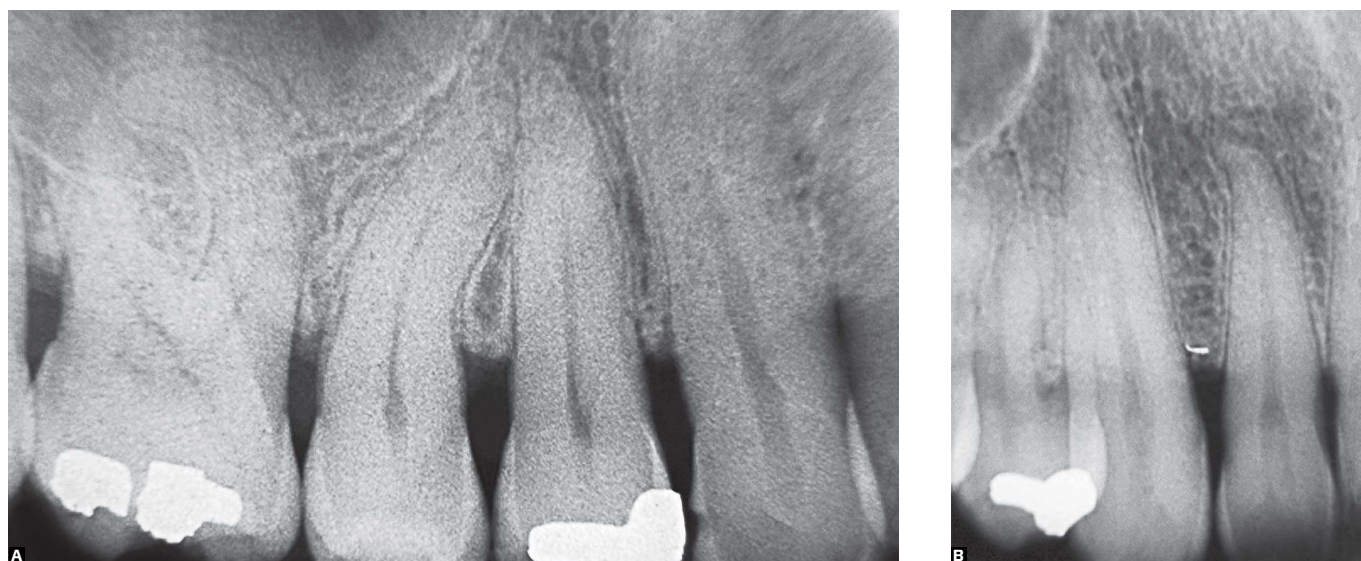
Initial radiographic aspect of type 2 DM patient. It can be observed mild horizontal bone loss.
